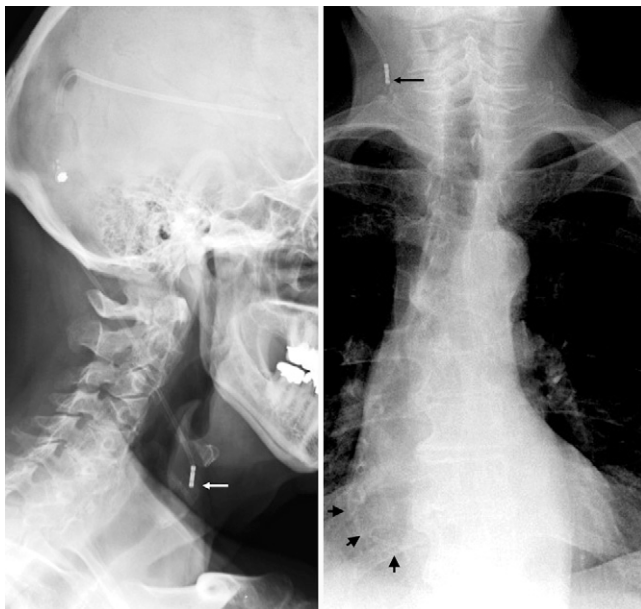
Case 2. Shunt disconnection with distal catheter in the right atrium. A: Lateral radiograph demonstrating a disconnection at the level of the straight connector (*white arrow*). B: Chest radiograph demonstrating disconnection proximally (*long arrow*) and distal catheter within the right atrium (*short arrows*).
